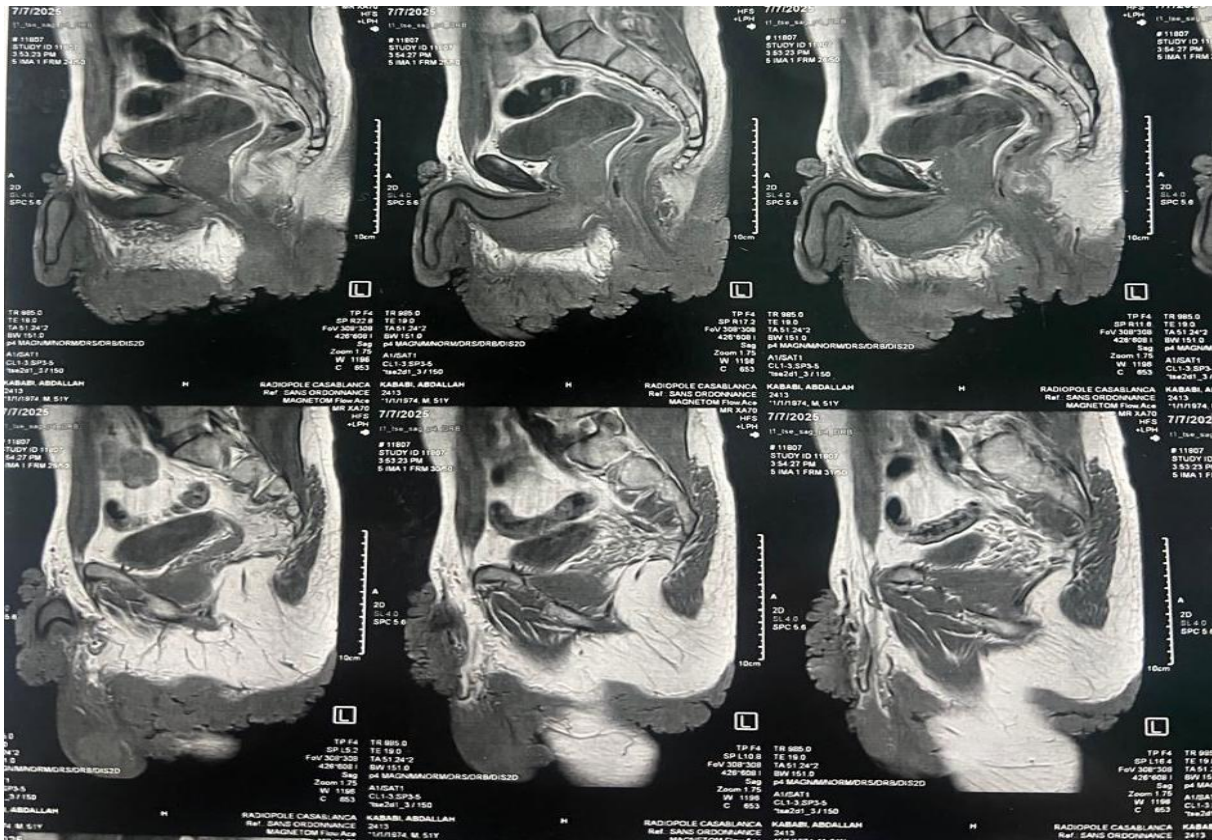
Pelvic MRI showing thickening of the scrotum extending to the inguinal and posterior perineal regions
